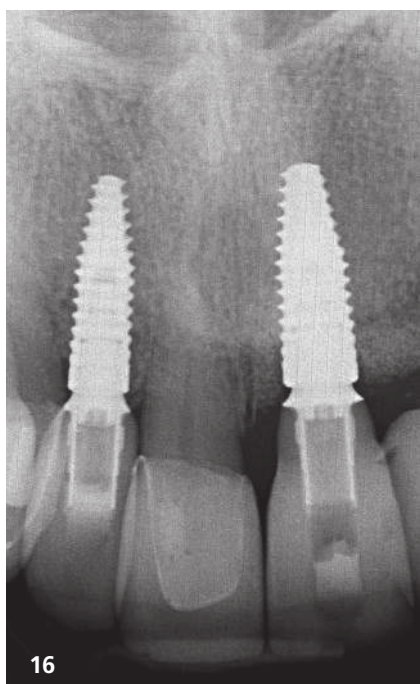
A follow-up radiographic evaluation assessed the long-term stability and health of the implant sites. – Fig. 17: Six-year follow-up showing favourable aesthetic results. – Fig. 18: Six-year follow-up demonstrating a satisfactory clinical outcome.
